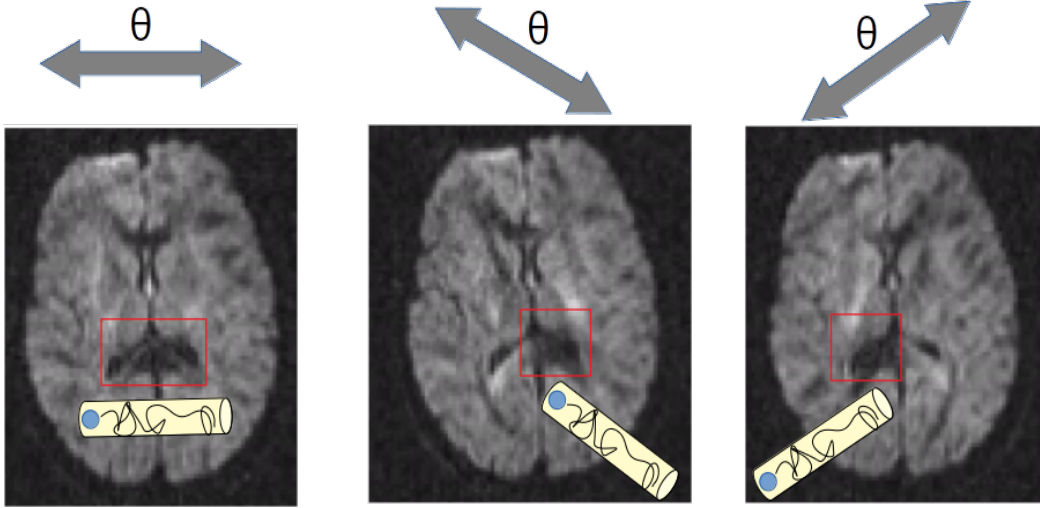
MR image intensity varies by applying different magnetic gradient directions.
